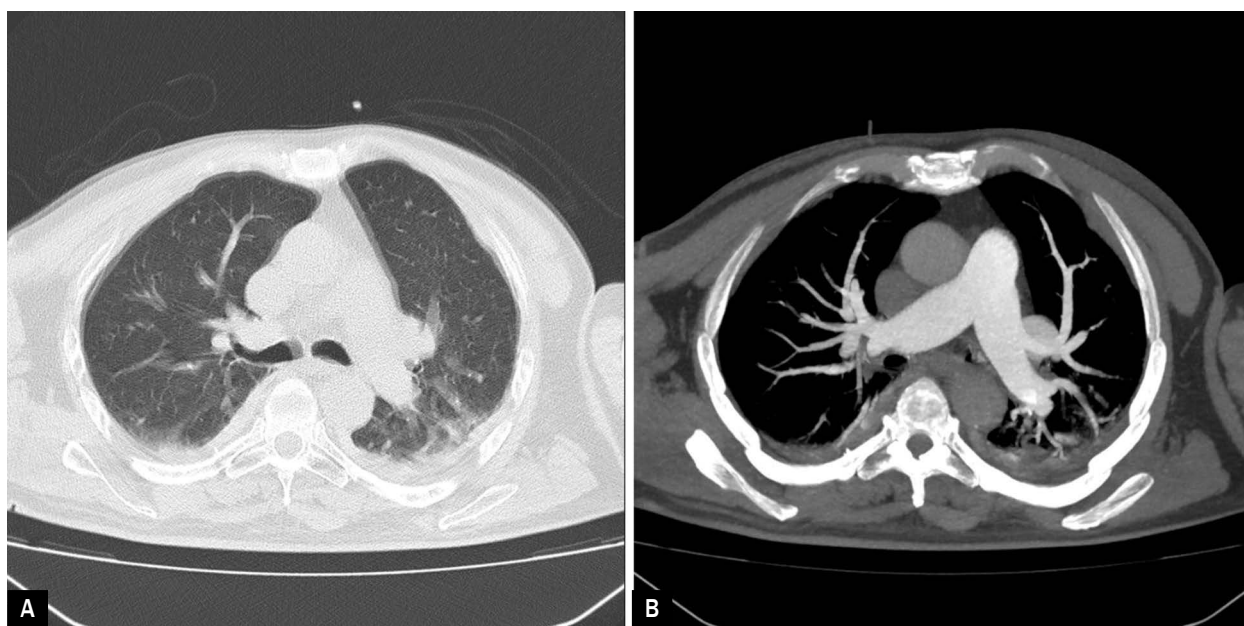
Chest computed tomography (CT) with motion artifacts showed bilateral pleural effusion and pulmonary consolidations; B. CT pulmonary angiography in maximum intensity projection (MIP) excluded embolic occlusion of the pulmonary arteries
